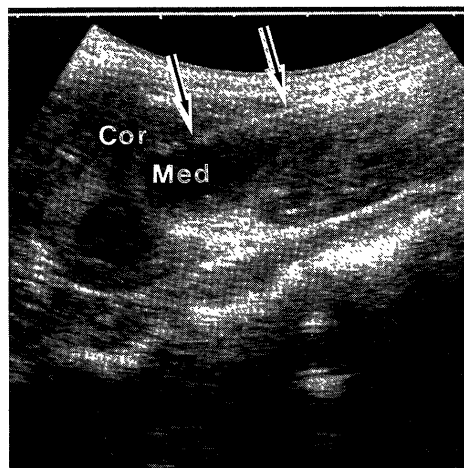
Ultrasonogram of the longitudinal axis of the right kidney. A biopsy needle (arrows) is penetrated into the renal cortex along the longitudinal axis. The minor axis of the kidney is too narrow for the biopsy.
